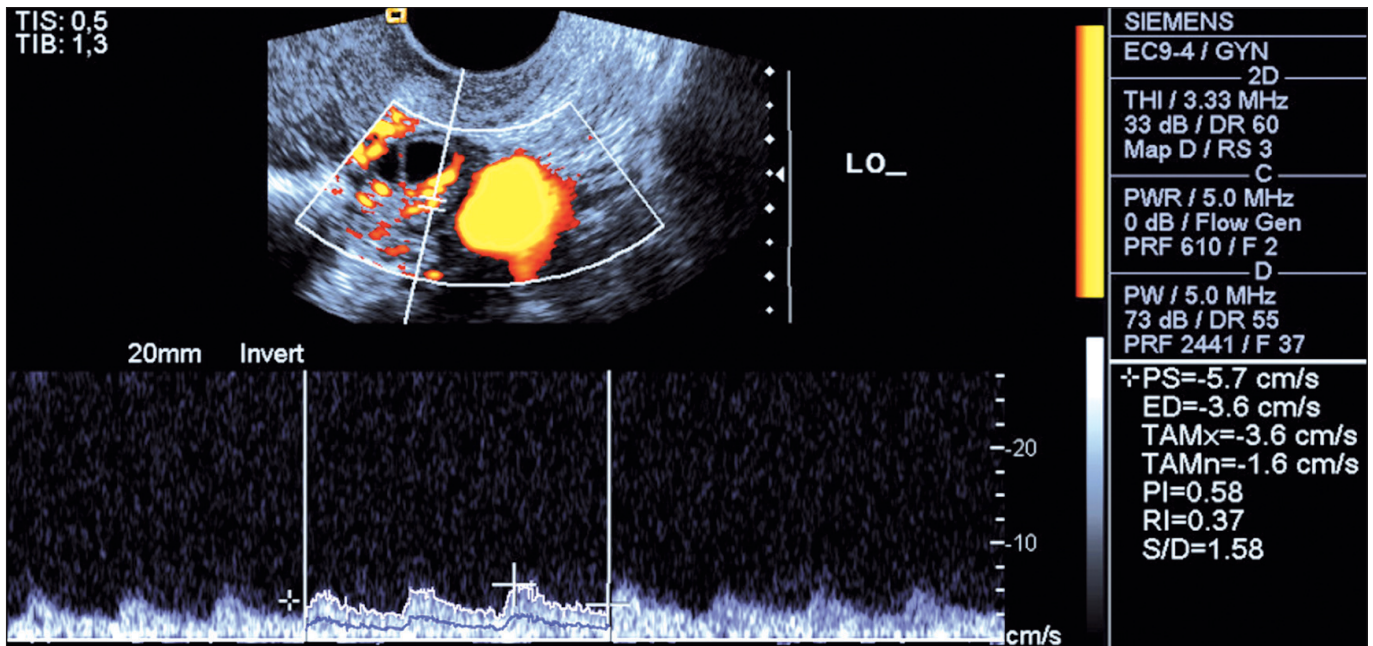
Power Doppler analysis of the ovarian stromal artery of a patient with BD in the early follicular phase of the menstrual cycle.
